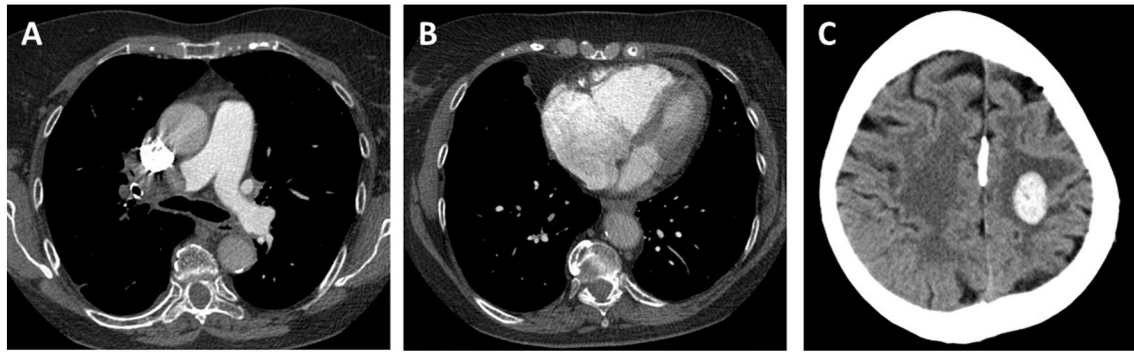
CT revealing central thrombus in the right pulmonary artery (A), RV dilatation (B) and intracranial bleeding (C). Contrast-enhanced CT showing a central thrombus in the right pulmonary artery (A) and dilatation of the right atrium and ventricle compared to the left atrium and ventricle (B). (C) Cranial CT revealed intracranial bleeding in the left hemisphere sized 2.2×1.4 cm.
